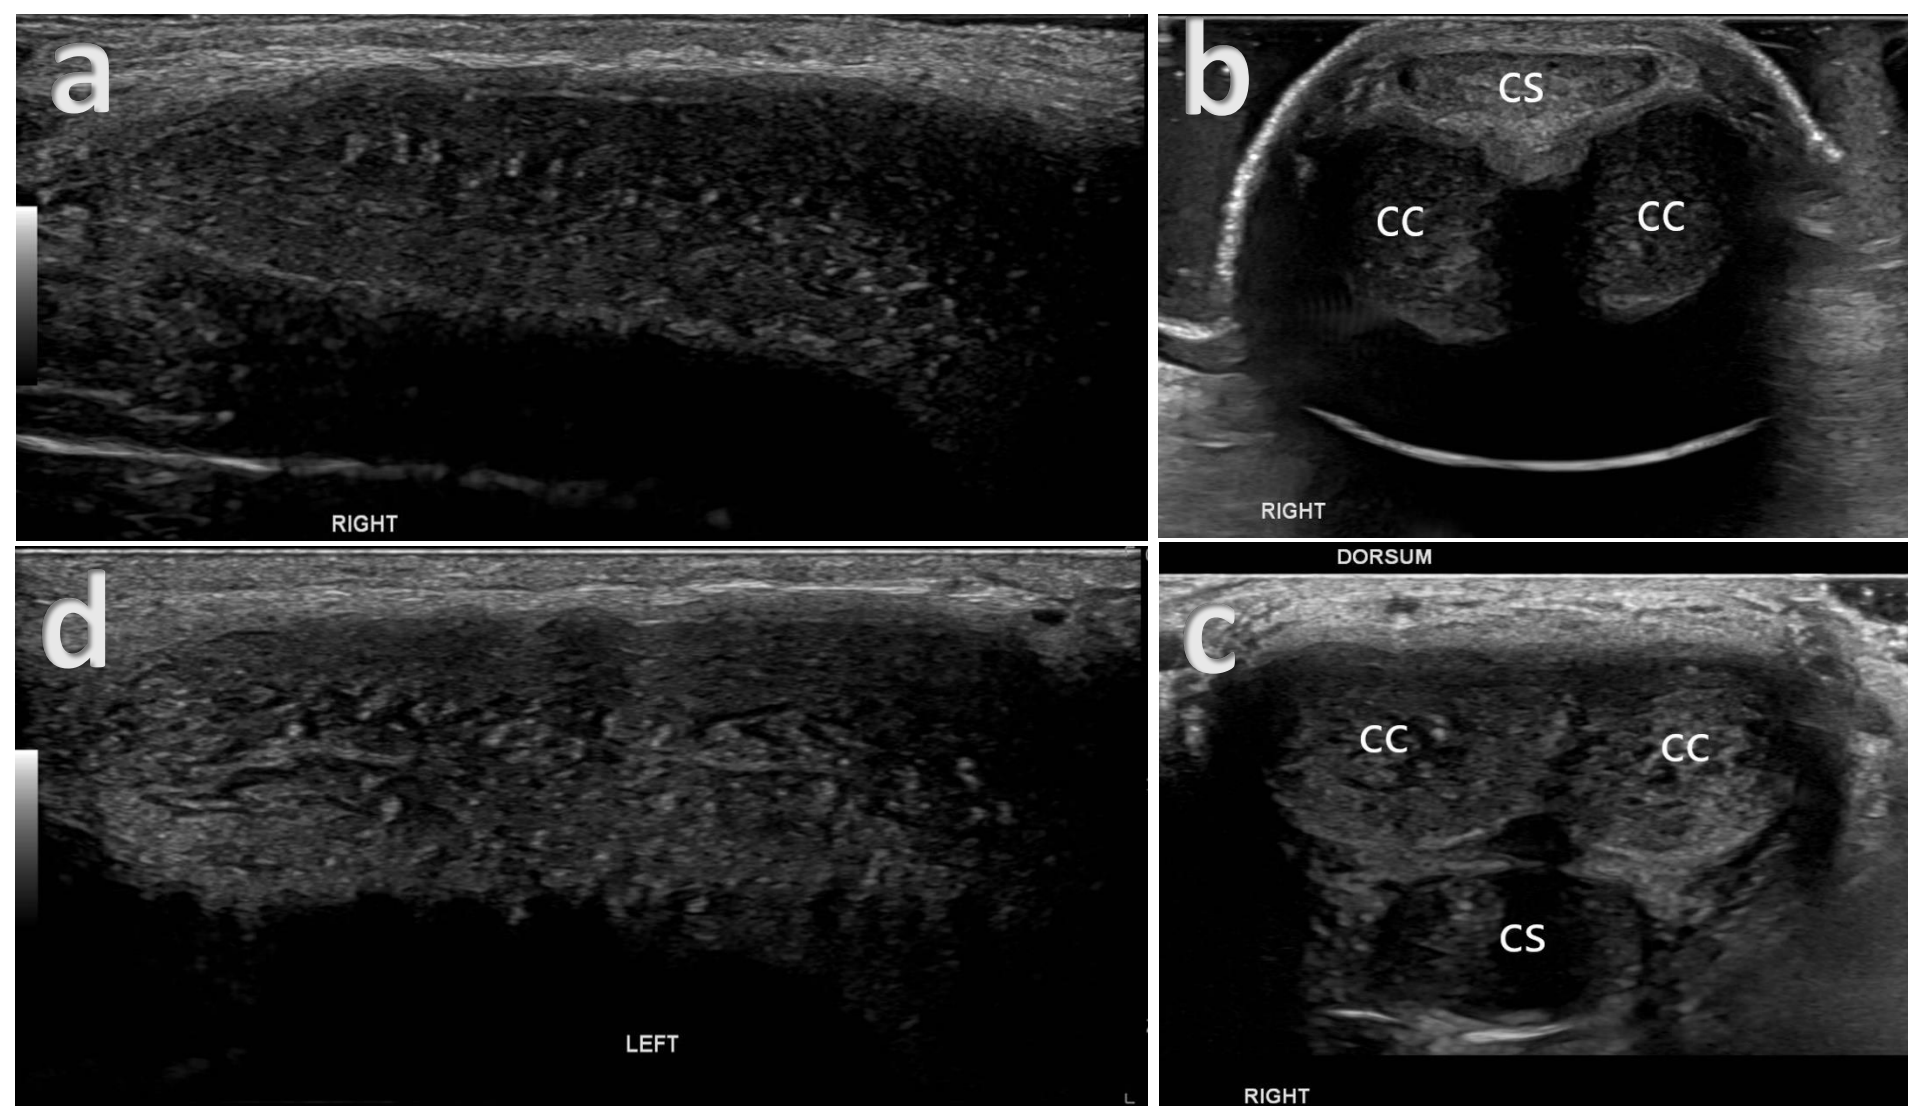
B-mode ultrasound of the penis depicting the cavernosal bodies. (a) and (d) showing longitudinal sonograms of the right and left corpora cavernosa (CC). (b) and (c) depicting an axial segment of the penis; with the ultrasound probe placed ventrally (b), while (c) was acquired dorsally where the corpus spongiosum (CS) appears posterior to the corpora cavernosa (CC).
